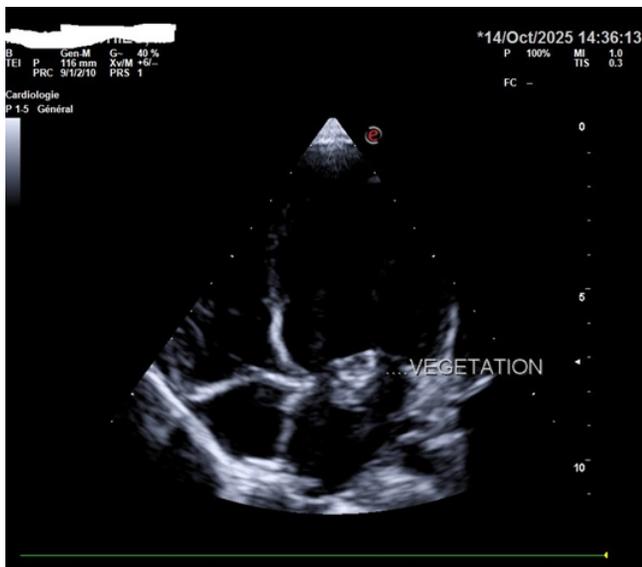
Four-chamber echocardiogram showing the presence of a vegetation on the atrial side of the mitral valve. The mitral valve is remodeled and thickened.
